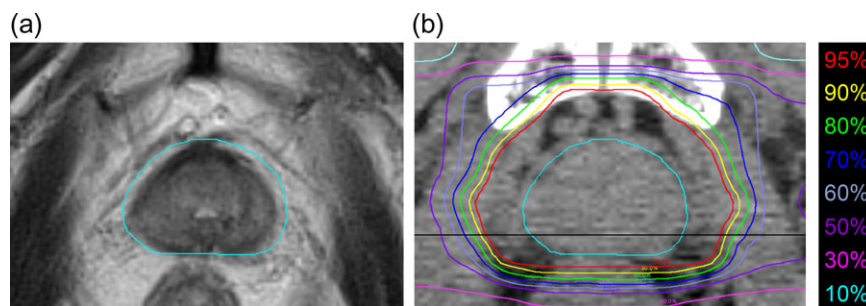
Example of MRI and planned CT images. (a) T2-weighted MRI before treatment (b) CT images with dose distribution. Cyan lines show prostate, and black straight line shows the isocenter. MRI signal intensity and the dose were measured in the pixels of the muscle on the black line.
